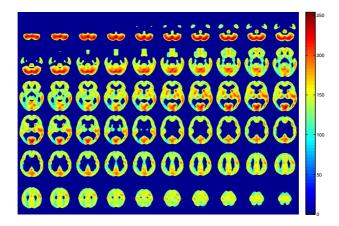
SPECT average image of the dataset once the mask has been applied
